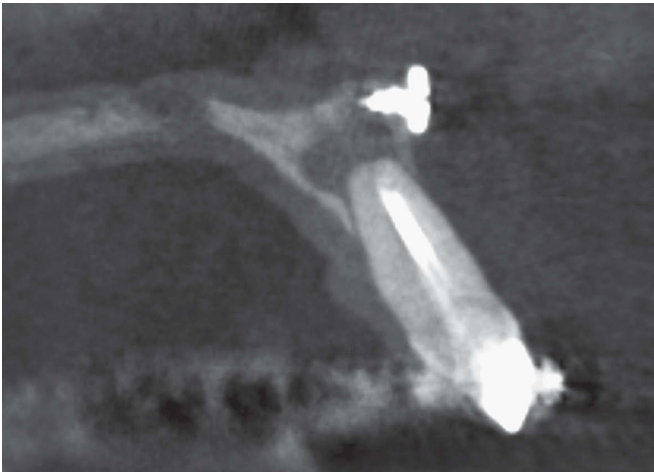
Sagittal and axial CBCT tomographic sections demonstrating periapical lesion.
